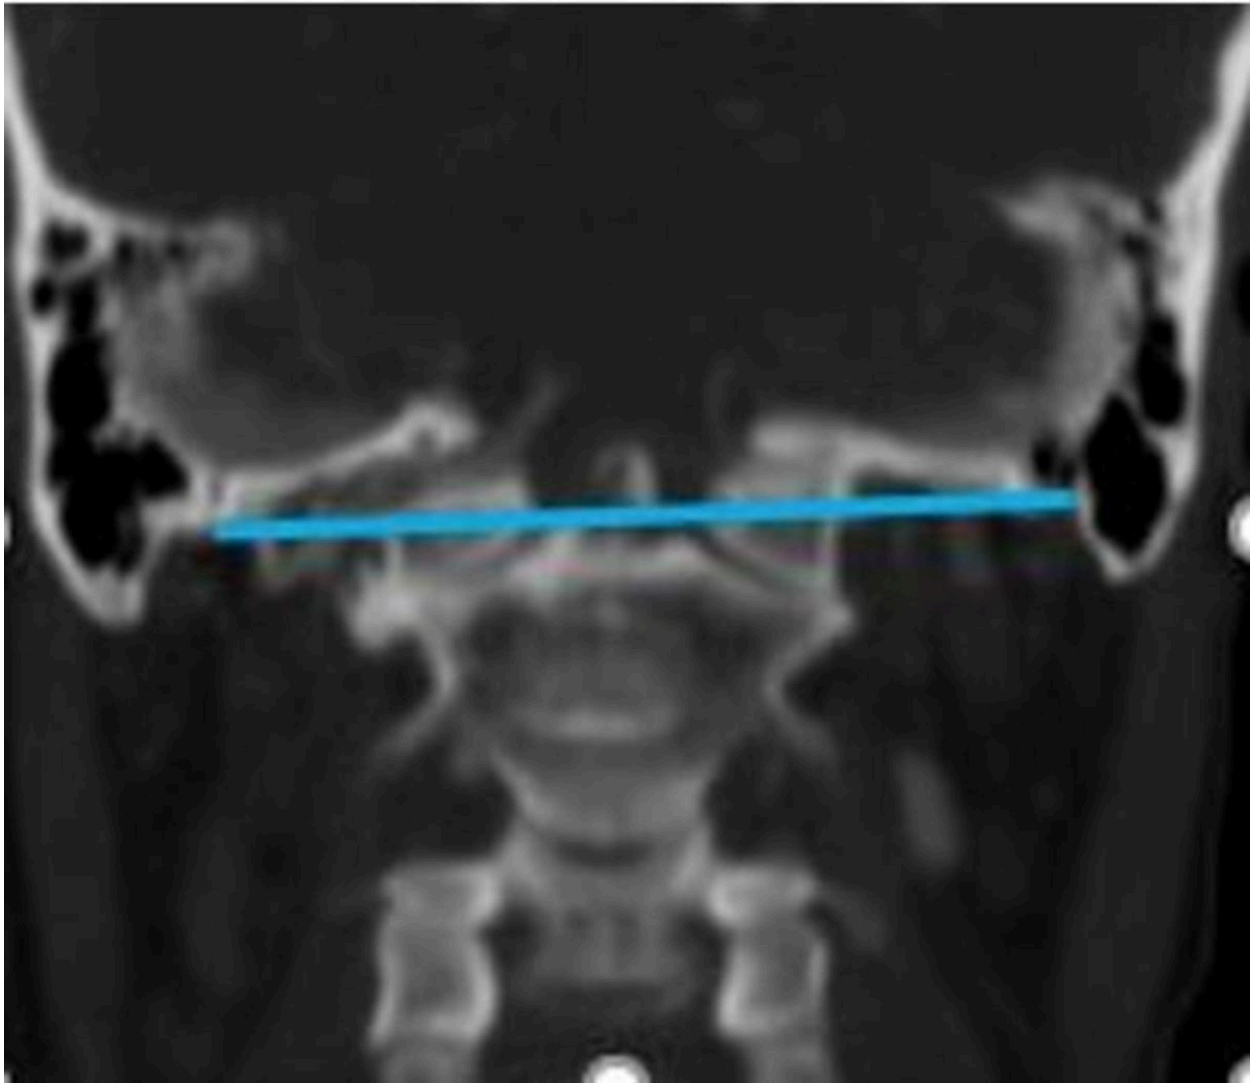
CT coronal section showing violation of Mc Gregors line in basilar invagination.
